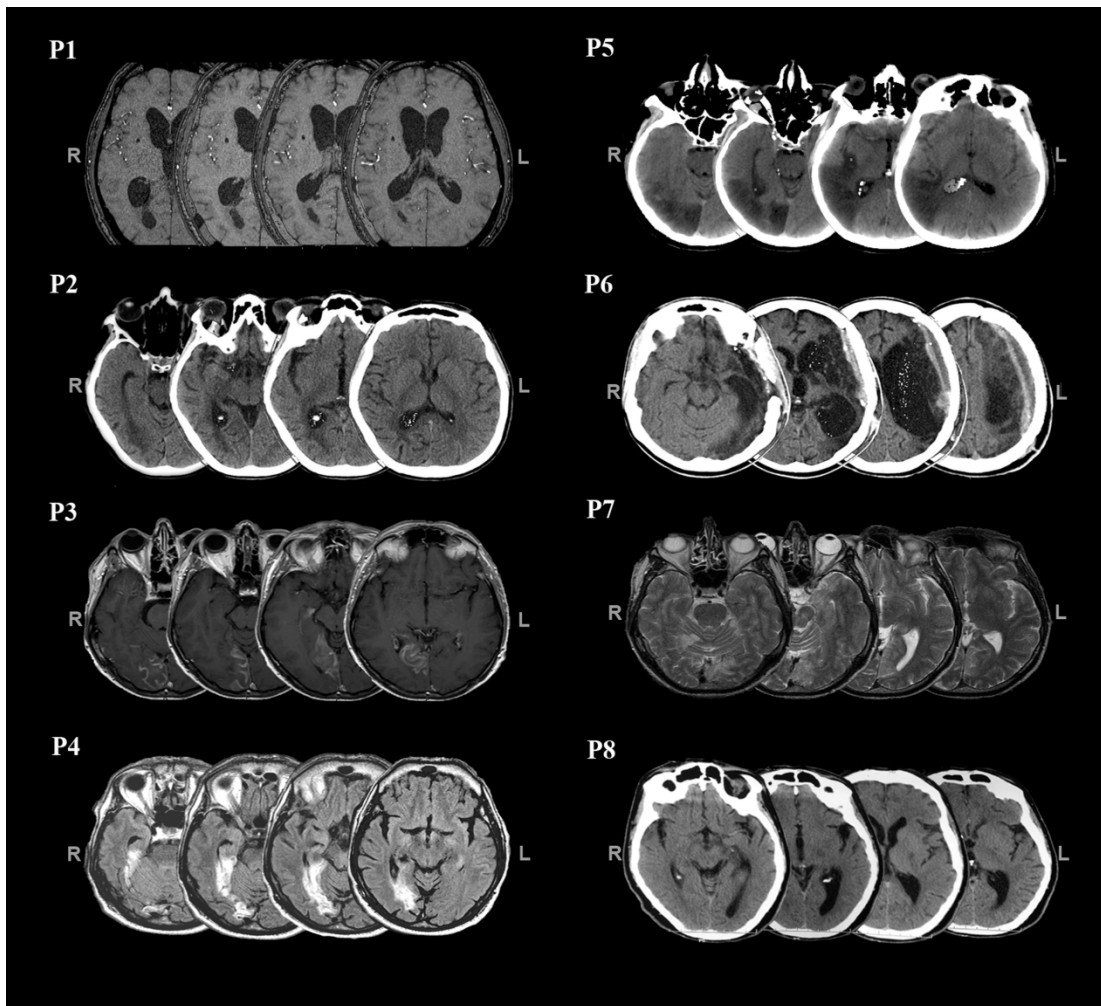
CT scan or MRI scannings of patients. All scans are presented in axial views. R: right; L: left.
